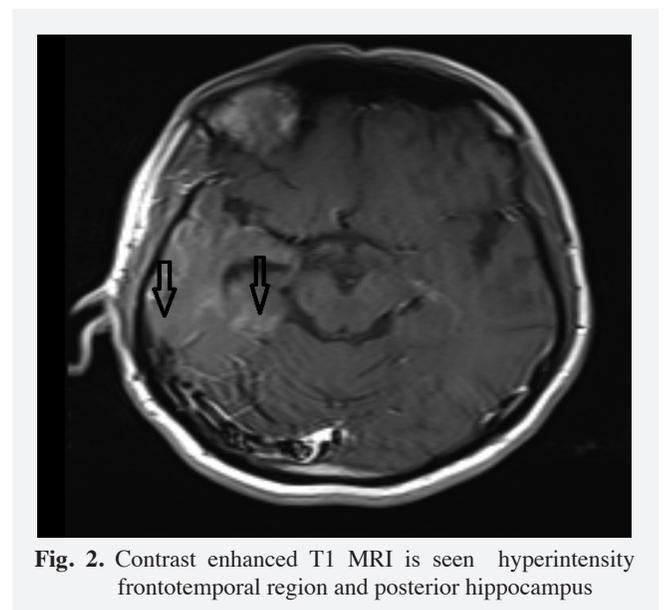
Contrast enhanced T1 MRI is seen hyperintensity frontotemporal region and posterior hippocampus
